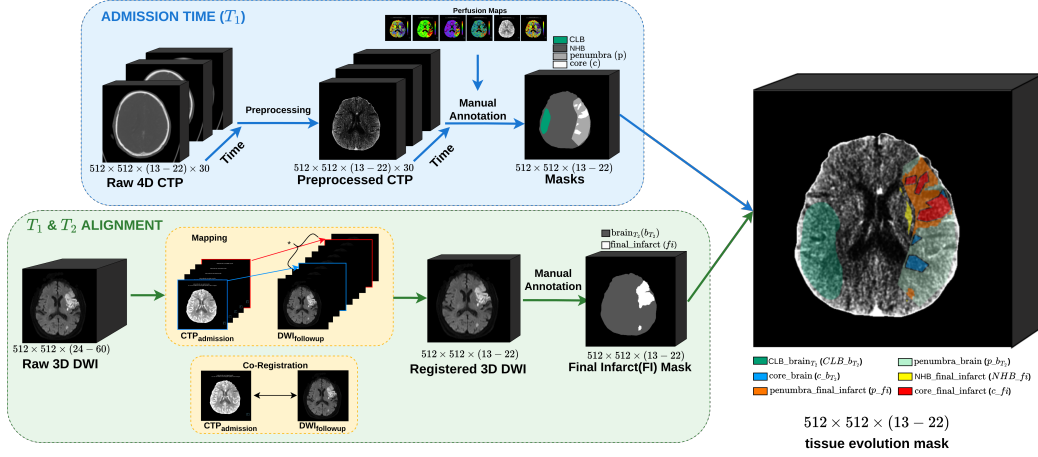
Construction of the tissue bi-temporal masks by combining manual delineation at admission (T_1) and follow-up (T_2). At T_1 , preprocessed 4D CTP is annotated into brain, penumbra and core. At T_2 , DWI is mapped to CTP slab and DWI co-registered to CTP is annotated for final infarct. The T_1 and T_2 masks are then merged into six-ROI mask.
